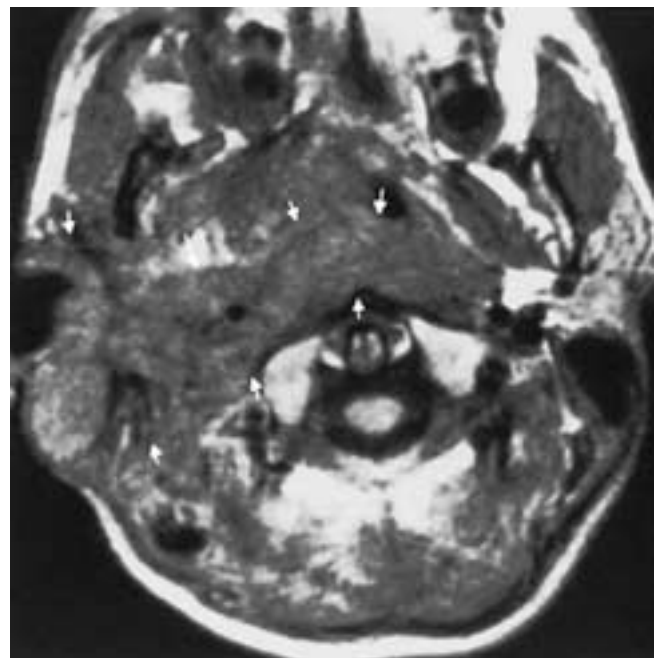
A patient with neurofibromatosis involving nasopharynx. Axial T1-weighted MR image through nasopharynx of 16-year-old demonstrates invasive mass that diffusely involves nasopharynx, retropharyngeal space, and carotid space. Mass is homogeneous and infiltrates throughout these spaces, as well as throughout subcutaneous tissue (*arrows*).
